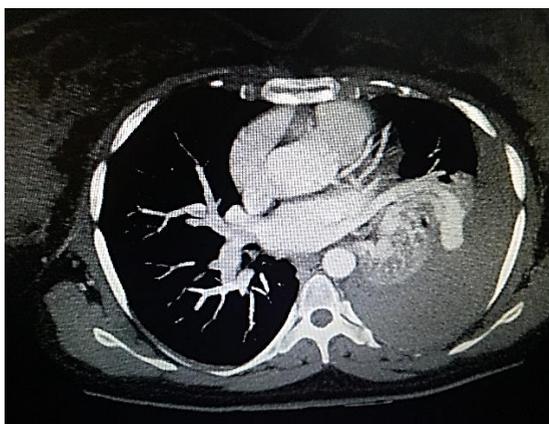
Computed tomography of the chest shows large venous sacs and prominent draining veins in the superior and anterior basal segments of the left lung
